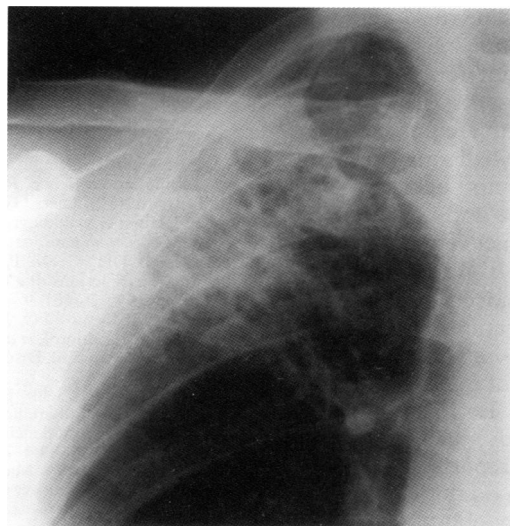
Chest radiograph of a patient with *M kansasii* infection showing multiple small cavities in the right upper lobe.
